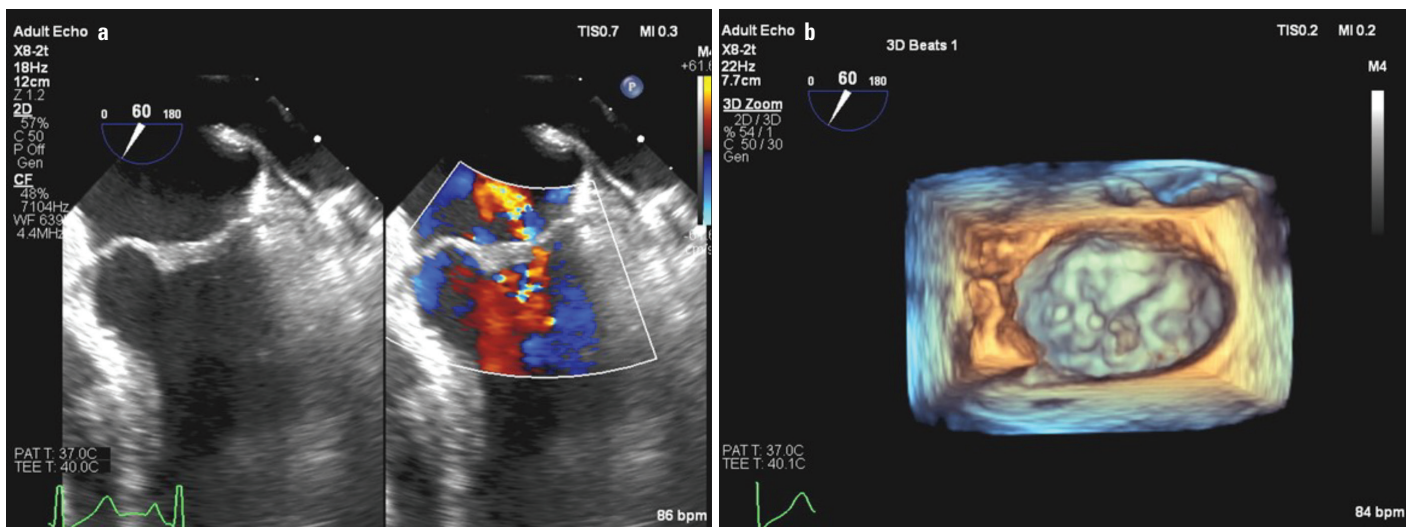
(a) Transesophageal echocardiogram demonstrating near complete resolution of the mass on the posterior leaflet and mild mitral valve regurgitation on color flow Doppler. (b) 3-dimensional transesophageal echocardiogram demonstrating a residual 1.2×0.3 cm mass on the A2 leaflet
